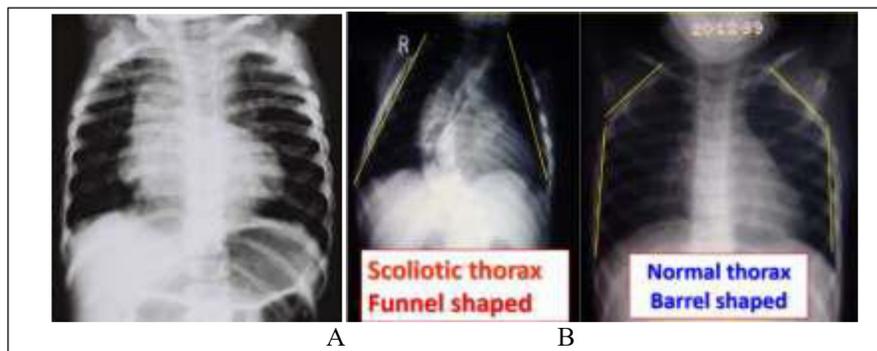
A. Chest radiograph of a normal girl aged 18 months, showing the difference in the shape of the thorax compared to a scoliotic RC of a IIS boy aged 19 months, B, (from Grivas et al 2006, [86]).
